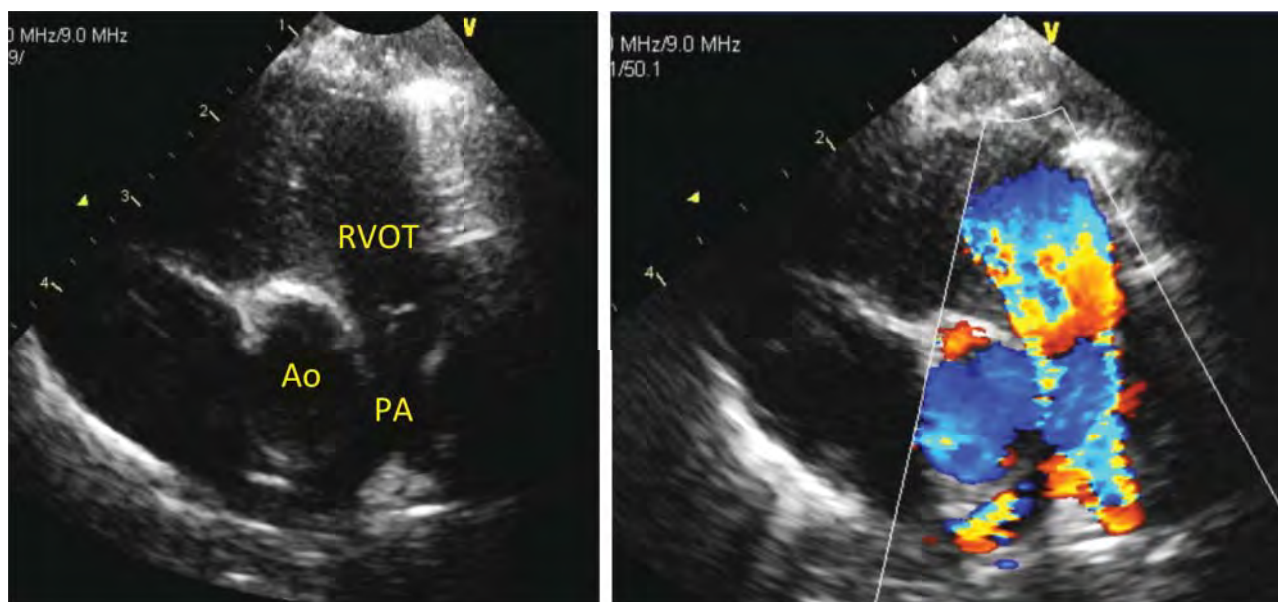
Parasternal short-axis view in two-dimensional and color Doppler imaging showing aliased flow in the right ventricular outflow tract (RVOT) and pulmonary arteries (PA).
